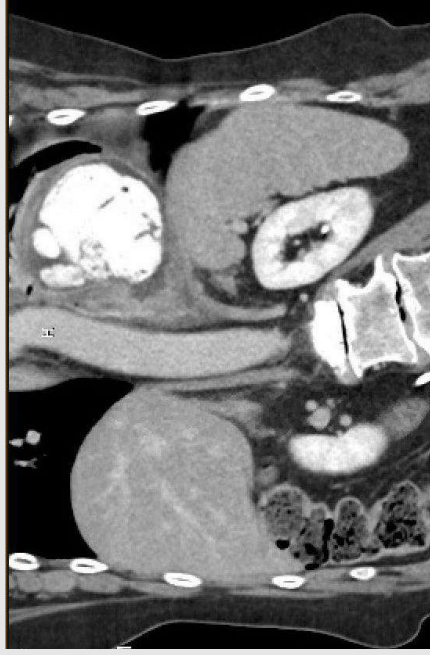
CT showing intrathoracic stomach with concern for volvulus as well as a moderate hemothorax.
